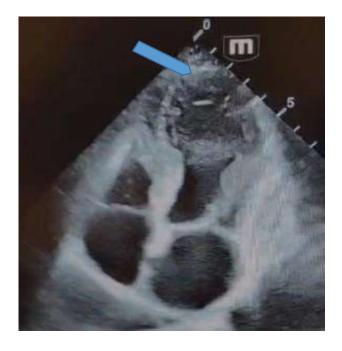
Echocardiography Image Apical Hypokinesis
